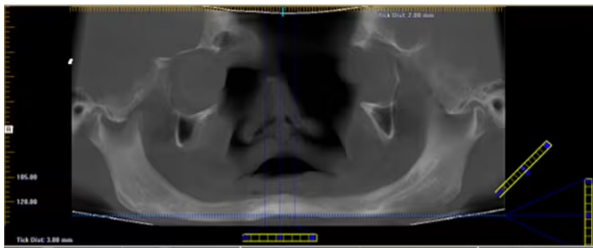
CBCT Panoramic Reformat to Assess Edentulous Mandibular Ridge
